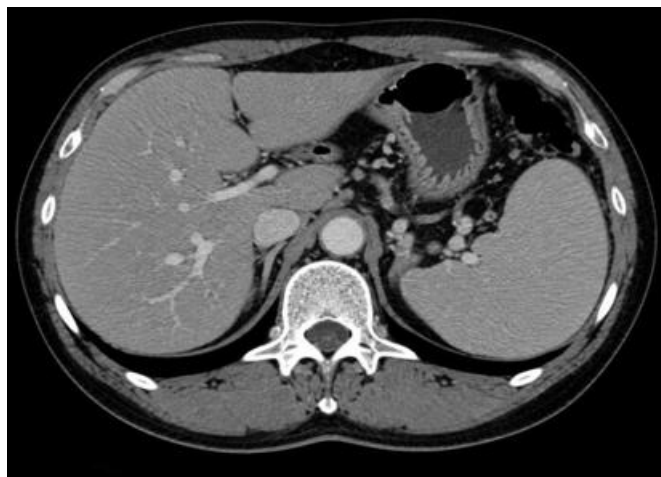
Axial contrast-enhanced CT image of the abdomen showing normal liver morphology, normal spleen size, and normal portal venous anatomy
